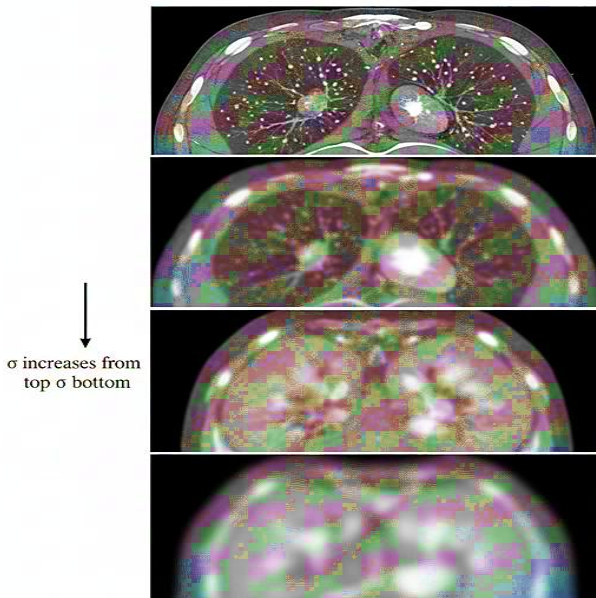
Linear scale-space stack of a lung CT slice (σ increases from top to bottom).
